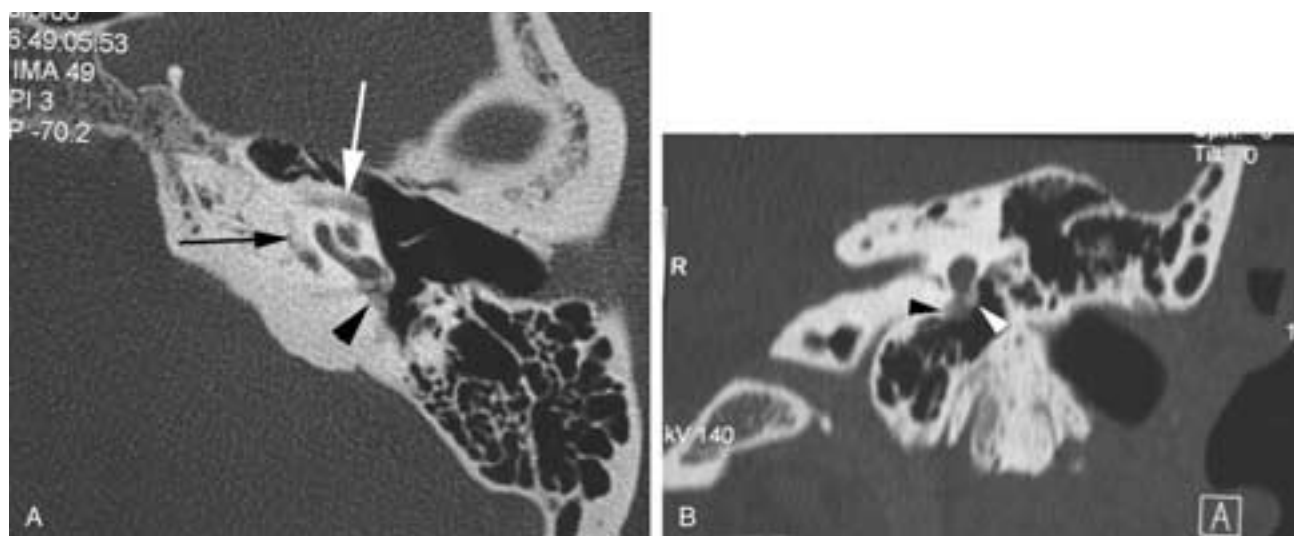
Fenestral and cochlear otosclerosis, CT scan. A, There is demineralization (*arrows*) around the cochlea. The demineralization seen just medial to the basilar turn is referred to as the fourth turn of the cochlea (double ring sign). Note the demineralized bone (*arrowhead*) impinging on the round window niche. B, Coronal image shows the demineralized bone both lateral (*white arrowhead*) and medial (*black arrowhead*) to the round window, causing narrowing.
